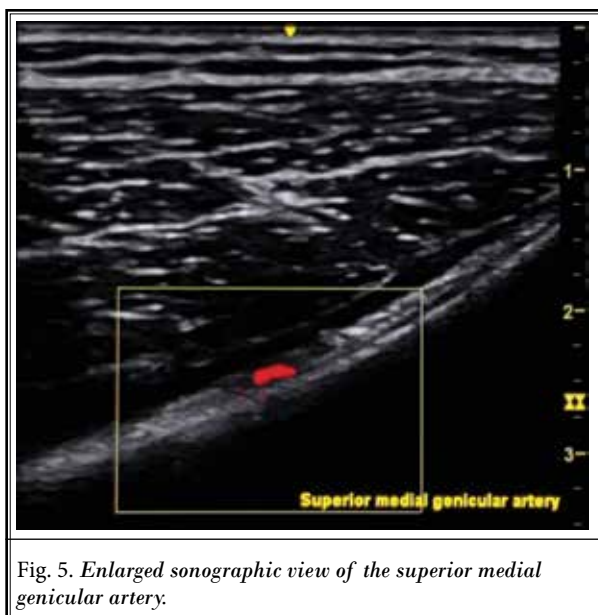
Enlarged sonographic view of the superior medial genicular artery.
